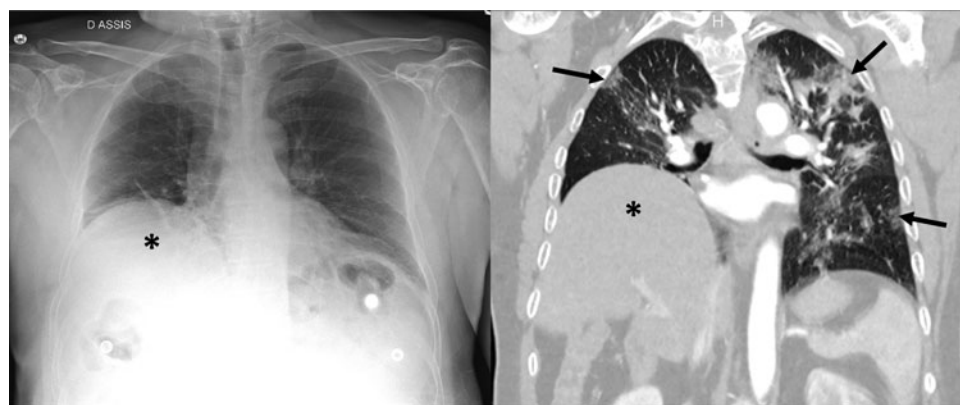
Pre-operative chest radiograph (left) and post-operative chest computed tomography (right) of patient 3, showing the appearance of diffuse ground-glass opacities with superior lobe predominance (arrows). Note a right diaphragmatic elevation (asterisk) that was present pre-operatively.
